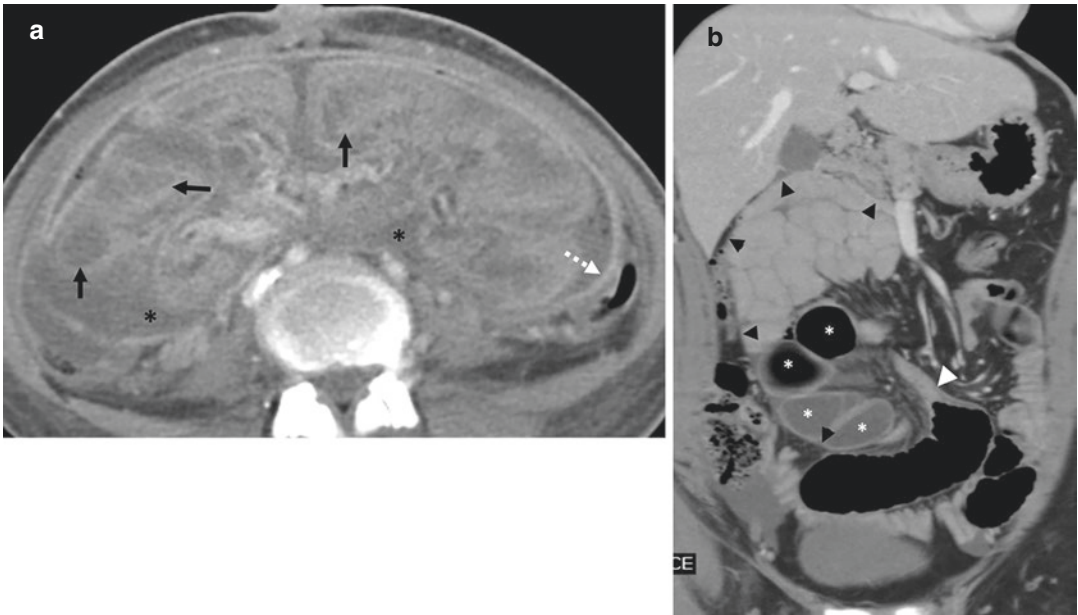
Abdominal cocoon: comparison of secondary versus primary types. (a) Cocoon secondary to peritoneal tuberculosis. Axial contrast-enhanced CT image shows encapsulation of thickened enhancing small bowel (black arrows) and locules of fluid (black asterisks) by thickened enhancing peritoneum (dashed white arrow). (b) Congenital cocoon/internal hernia causing closed loop obstruction due to small bowel malrotation. Coronal
